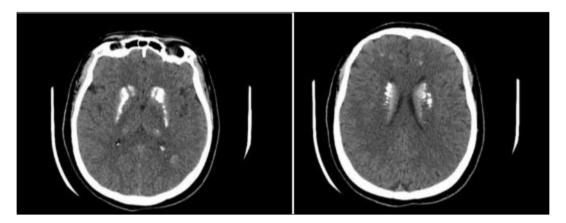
Brain CT scan showing caudolenticular calcifications
